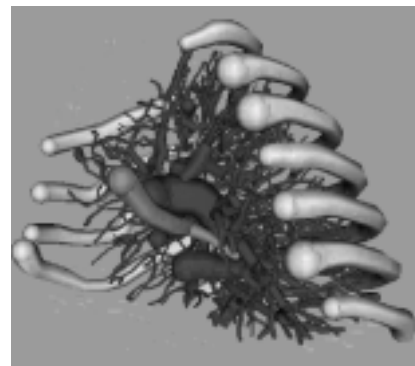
Vessels, bronchi and ribs extracted from chest CT.
